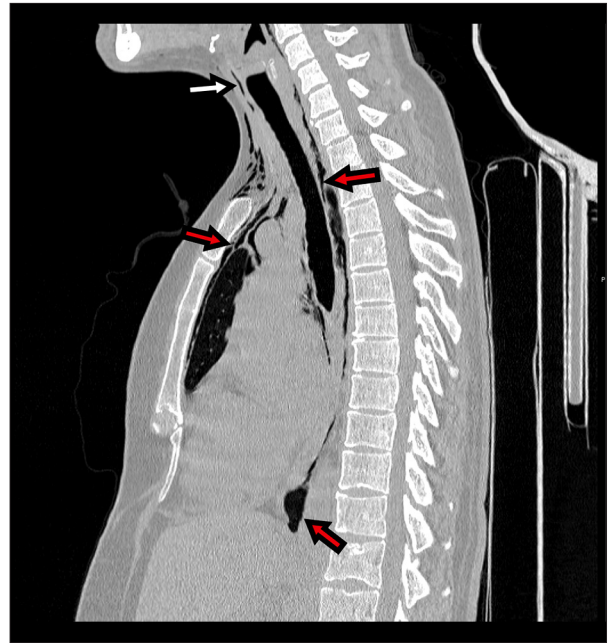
Sagittal neck and chest computed tomography scan demonstrates free air in the subcutaneous tissue of the chest and neck (white arrows) and gas surrounding the vessels, esophagus, trachea, and posterior pericardium (red arrows).
